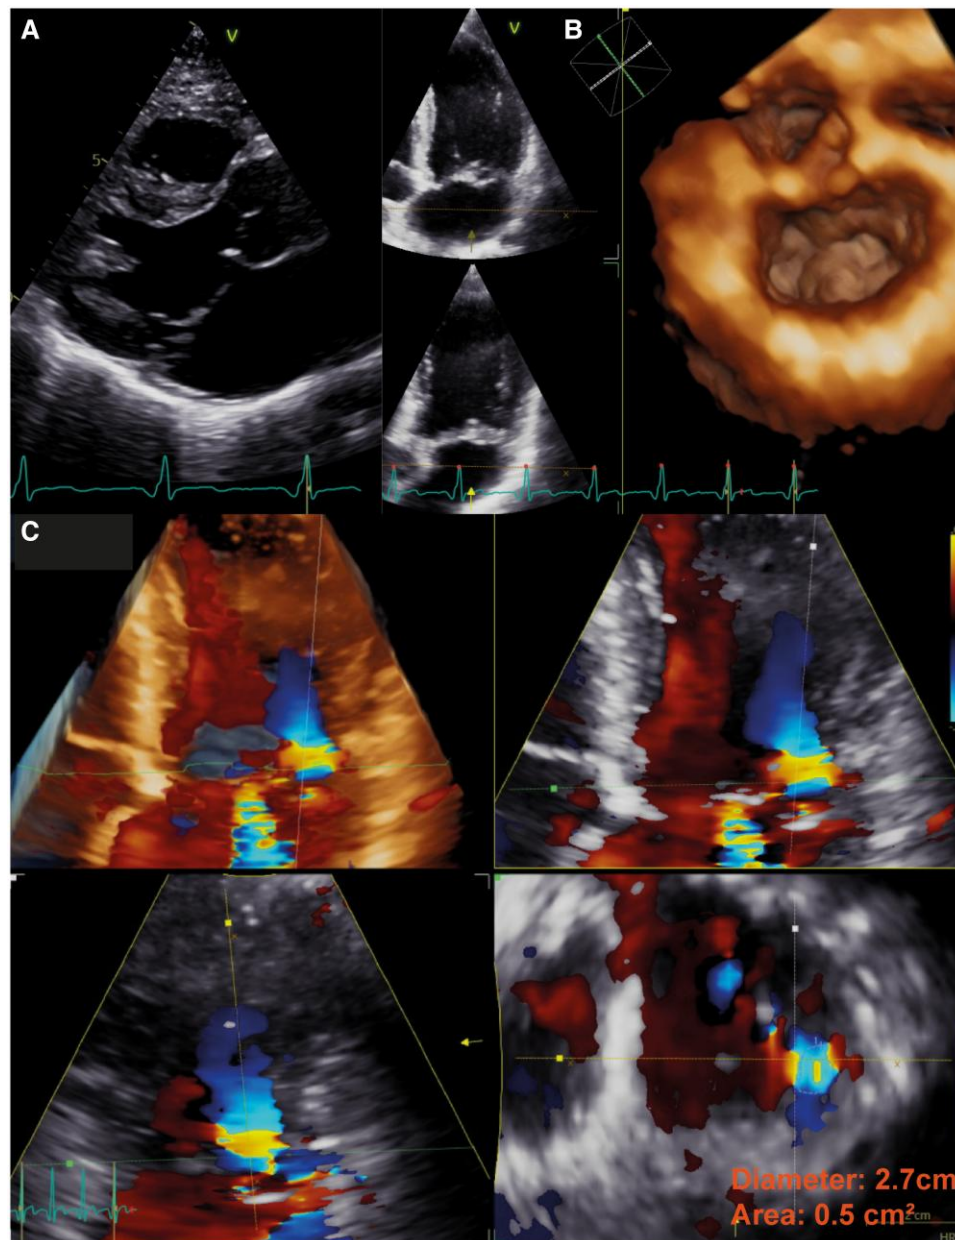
Primary mitral regurgitation (MR) in a 55-year-old woman. In women, mitral valve prolapse often presents with more complex anatomy and frequent bi-leaflet involvement. In this case, significant prolapse of the A2 and P2 scallops—more pronounced in P2—(panels A and B) resulted in severe MR with an eccentric regurgitant jet. The measurement of the 3D vena contracta was performed using 3D transthoracic echocardiography (panel C).
